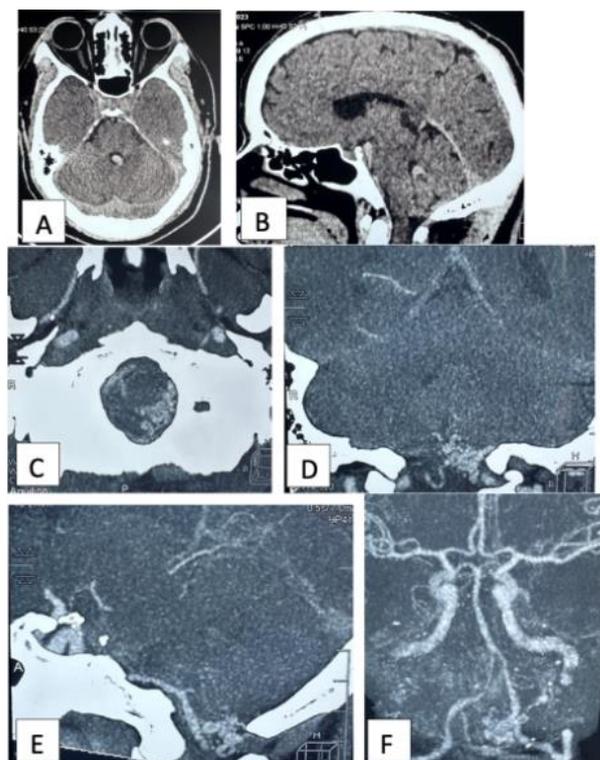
Brain CT scan, axial (A), sagittal (B) showing SAH fisher.
